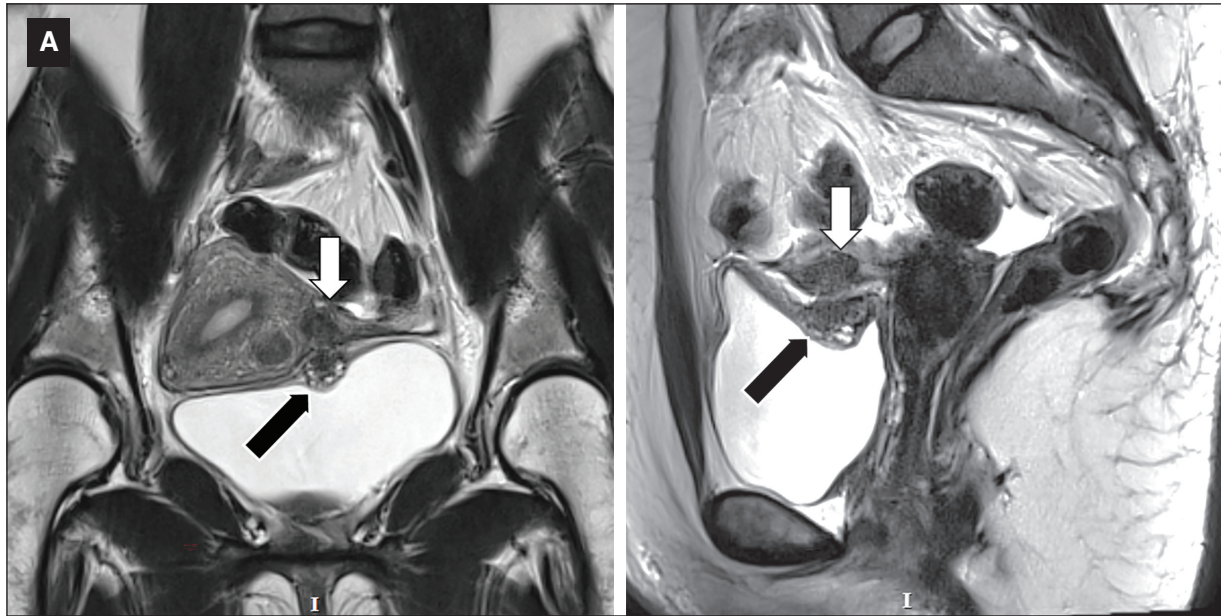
Bladder endometriosis in a 33-year-old woman with dysuria and chronic pelvic pain. A: coronal and B: sagittal T2-weighted MRI demonstrating a nodule with low signal intensity and small cystic areas (black arrows) attached to the posterior bladder wall, deeply infiltrating the detrusor muscle. A nodular thickening of the left round ligament is also seen (white arrows), adhered to the bladder nodule. MRI: magnetic resonance imaging.
